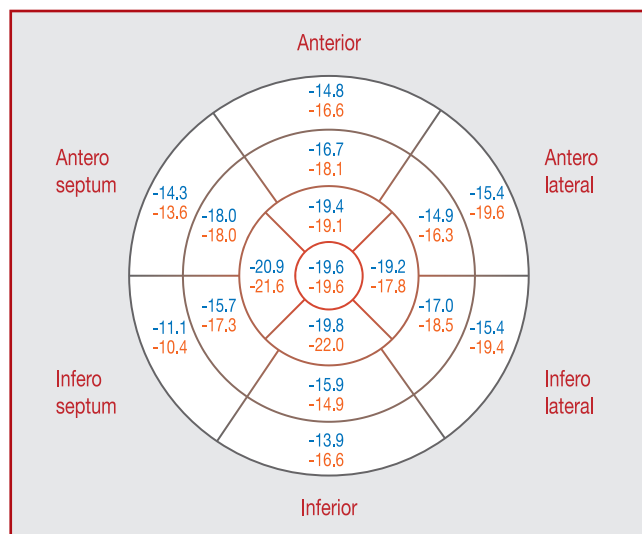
Mean segmental longitudinal strain values for General Electric (blue) and Philips (orange) in a 17-segment American Society of Echocardiography left ventricular model.
